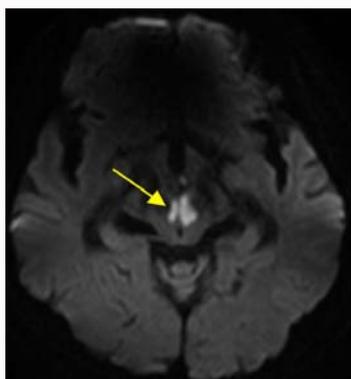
Axial DWI sequence (b1000) showed restricted diffusion in the paramedian thalamus and central midbrain (yellow arrow). The ADC map showed a low apparent diffusion coefficient (image not shown).
